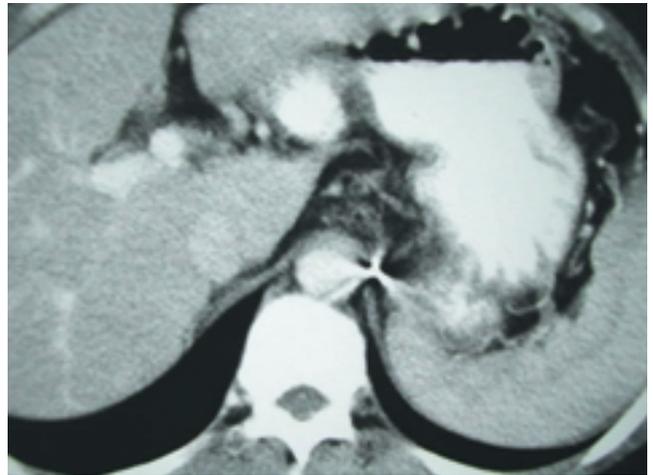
One months follow-up CT shows that gastric varices have disappeared. There is a metallic artifact from the microcoil.
